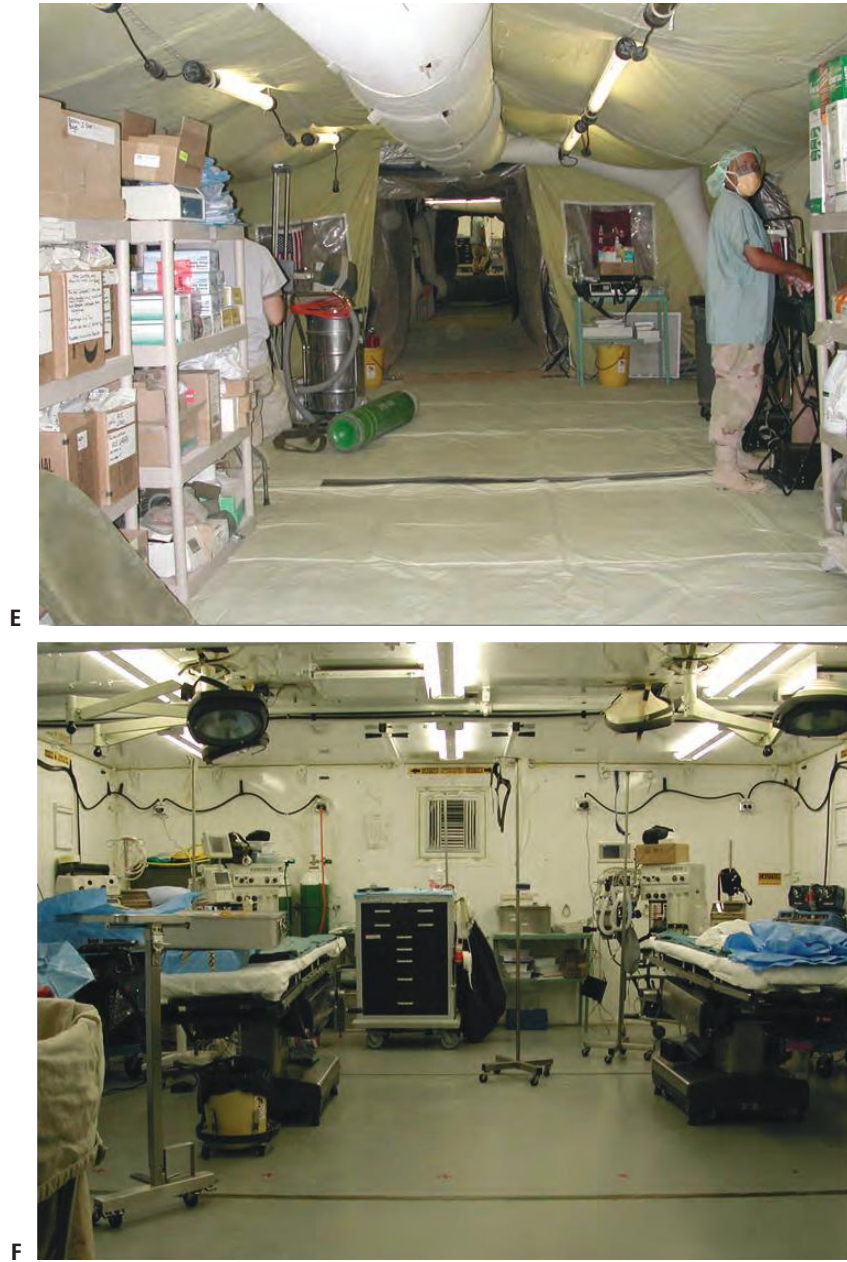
Level 3: Combat Support Hospital. A. As can be appreciated from this photograph, heat and dust associated with the Baghdad CSH is environmentally unfriendly to advanced neuroimaging. Nevertheless, digital X-ray, CT, fluoroscopy, interventional radiology, and ultrasound are usually present at the CSH. Magnetic resonance imaging (MRI) became available in Afghanistan in 2011. The CSH consists of about 250 beds and 550 personnel. These facilities are similar to a moderate-sized community hospital in the United States with emphasis on trauma management. Casualties who are not able to return to their units within 1 week are aeromedically evacuated to [Level 4](#) care. B. Receipt and recovery area. (*Continued*)
